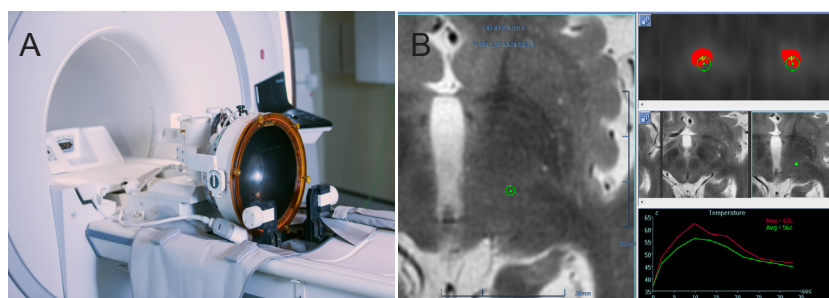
Focused ultrasound thalamotomy for treatment of essential tremor.
